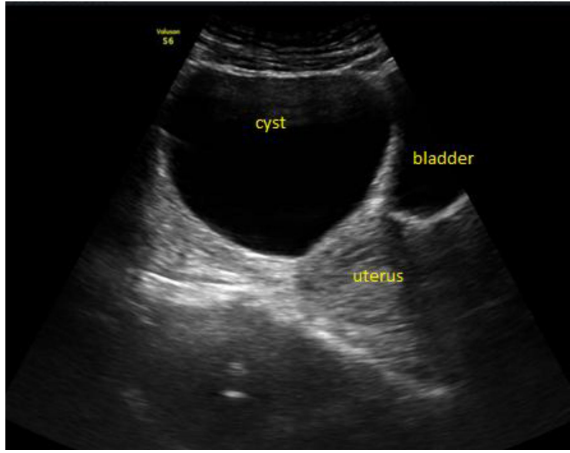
Transabdominal sonogram showing, a large well defined Unilocular cyst in right adnexa
